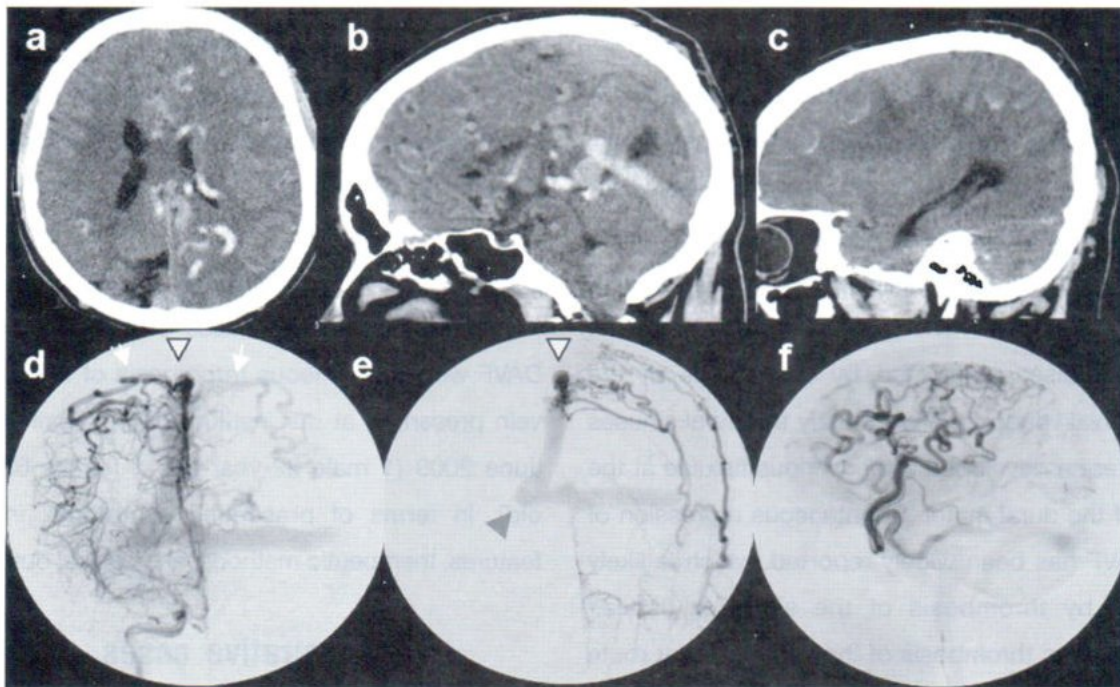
Non contrast brain CT scan axial (a) mid-sagittal (b), right parasagittal views (c) showed multiple hyperdense vessels at the midline and left parasagittal region with hyperdensities within the Galenic vein and straight sinus. Tonsillar brain herniation was evident in the mid sagittal view. Patchy hypodensities were seen at the right cerebrum white matter as well as curvilinear subcortical calcifications, a finding of chronic venous congestion. Right ICA angiogram late arterial phase (c) and left external carotid angiogram (d) AP view showed DAVF at the middle 1/3 of the SSS (arrow heads) with occlusion of the right transverse sinus (read arrow) and bilateral CVR (yellow arrows). Left ICA angiogram lateral view capillary phase (f) showed the appearance and drainage route of the left-sided CVR.
